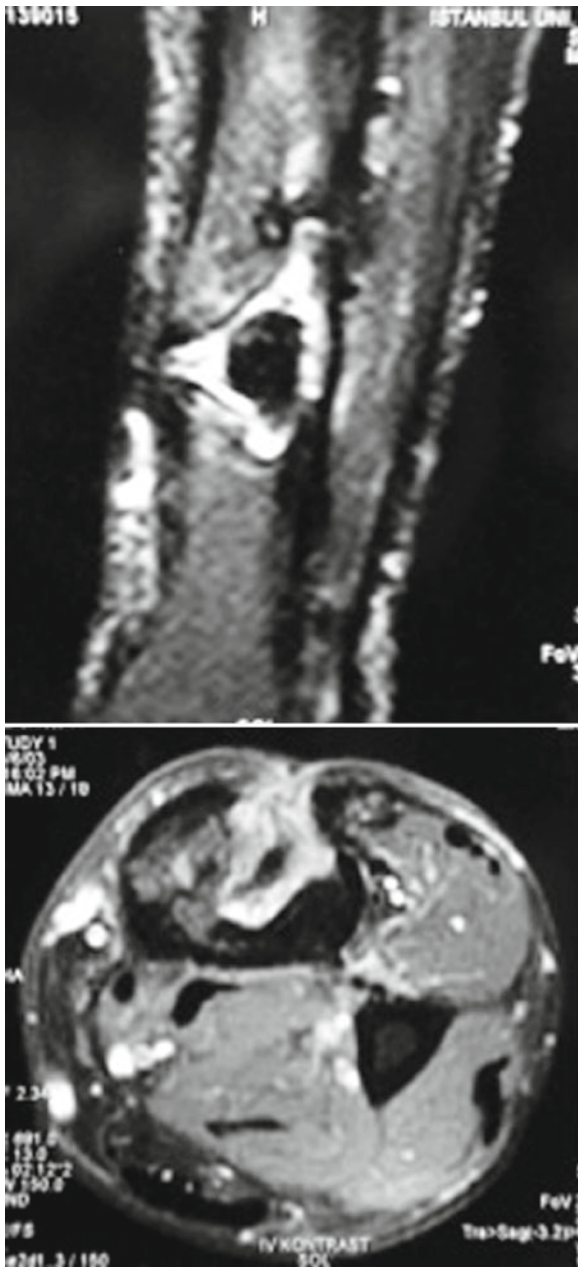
MRI from a patient with chronic posttraumatic osteomyelitis, displaying a sequestrum and fistula tract
